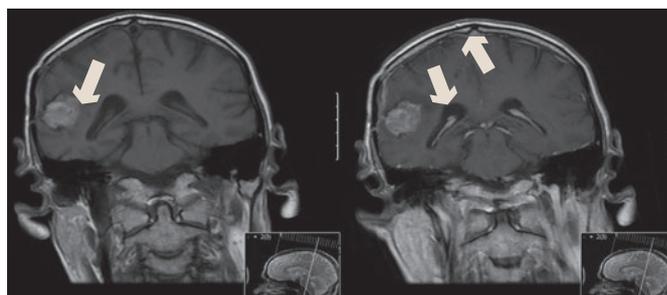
Post-treatment Magnetic Resonance Imaging of Brain
